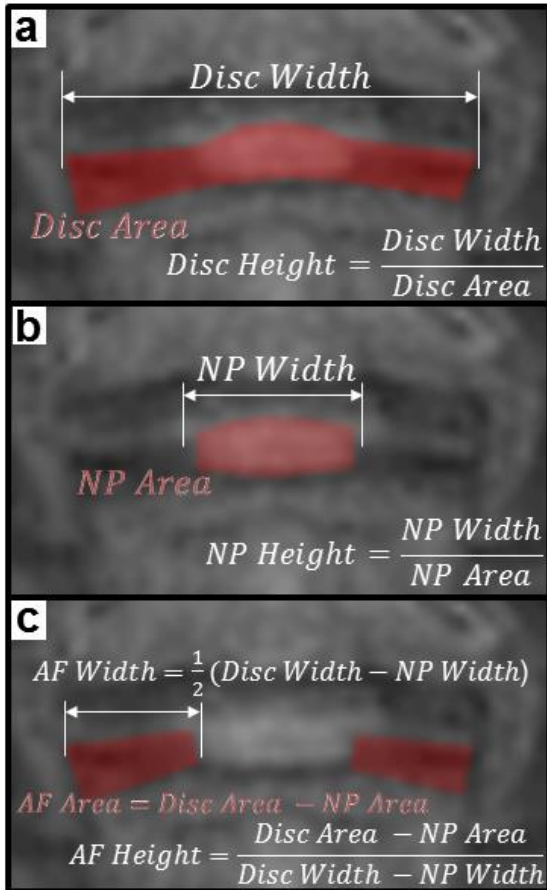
4 Geometry analysis for MR images. (a) Whole disc dimensions as estimated by manual tracing, (b) NP dimensions as determined by bimodal, bivariate auto-segmentation, (c) AF dimensions as the regions excluded by auto-segmentation.
